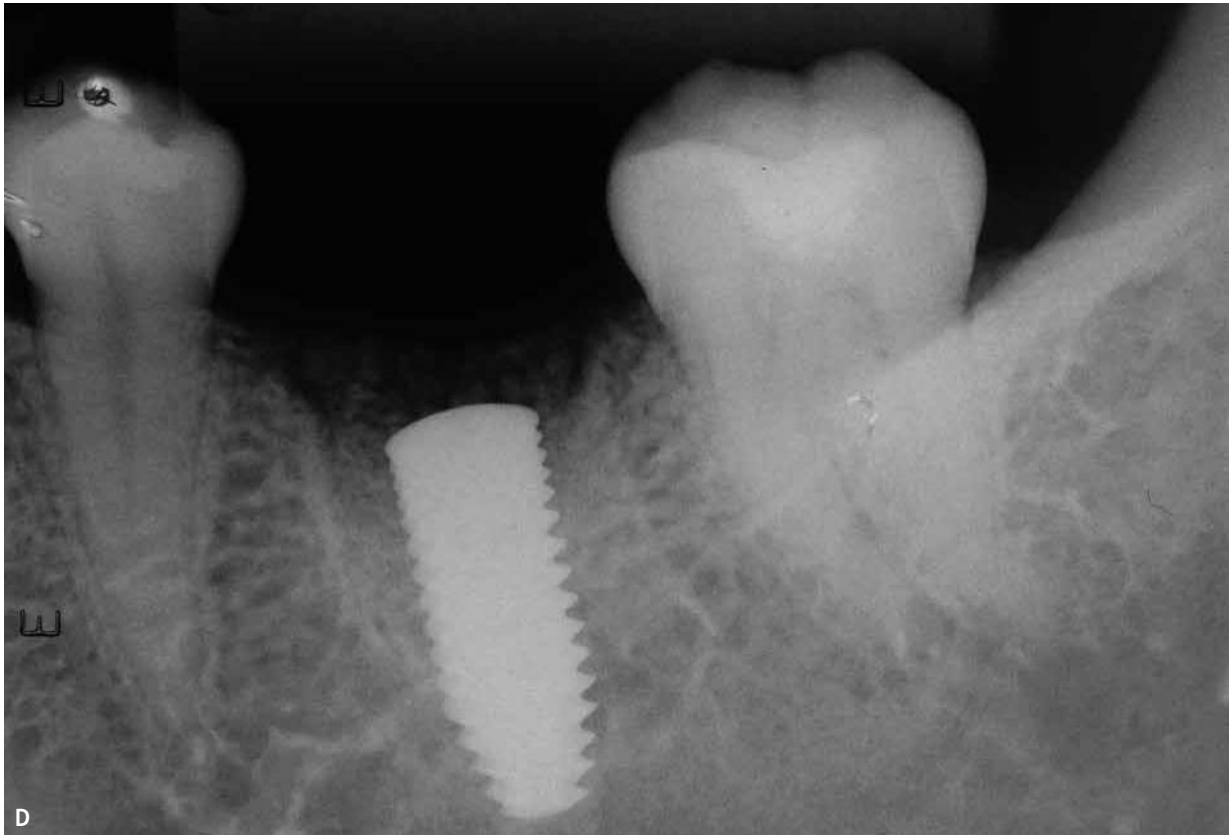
(AD) - A) 21-day postoperative period. B) 30-day postoperative period. C) 60-day postoperative period. D) 90-day postoperative X-ray.
